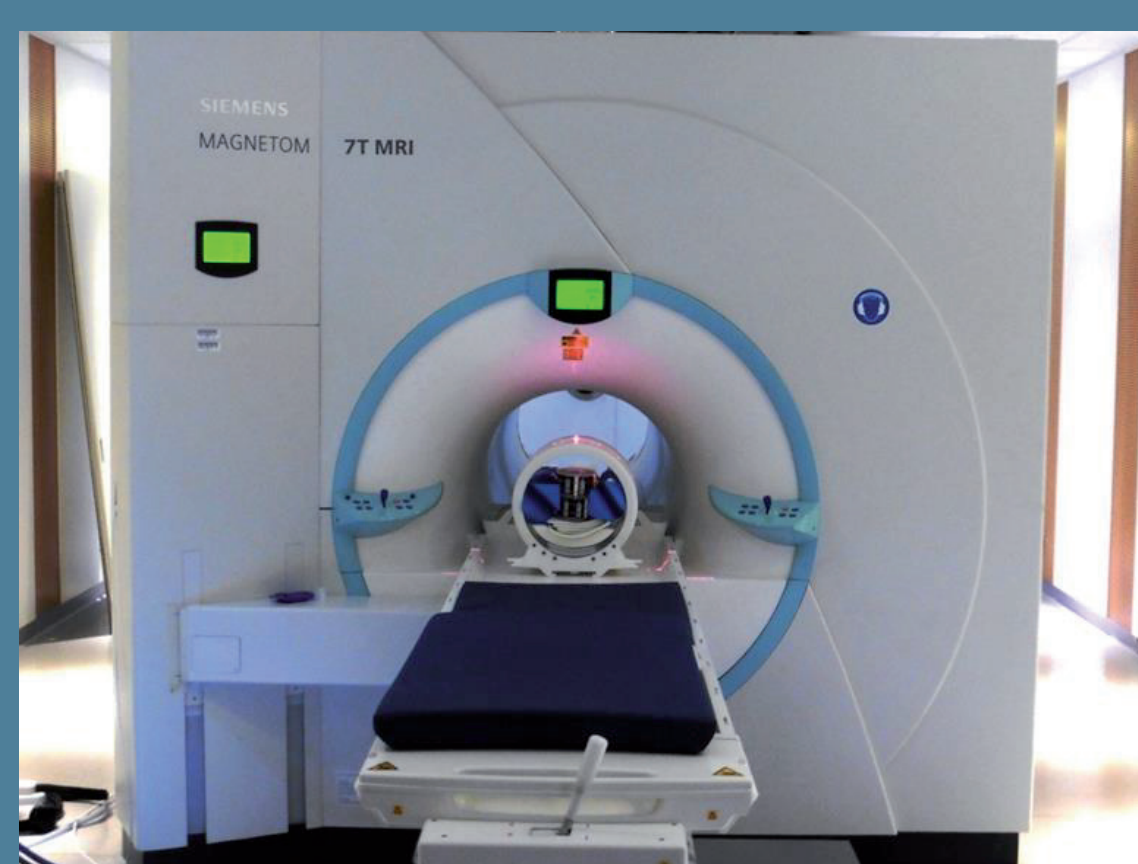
MRI-scanner 7 T with TLDs positioned inside a RF-coil to investigate a potential RF-impact
